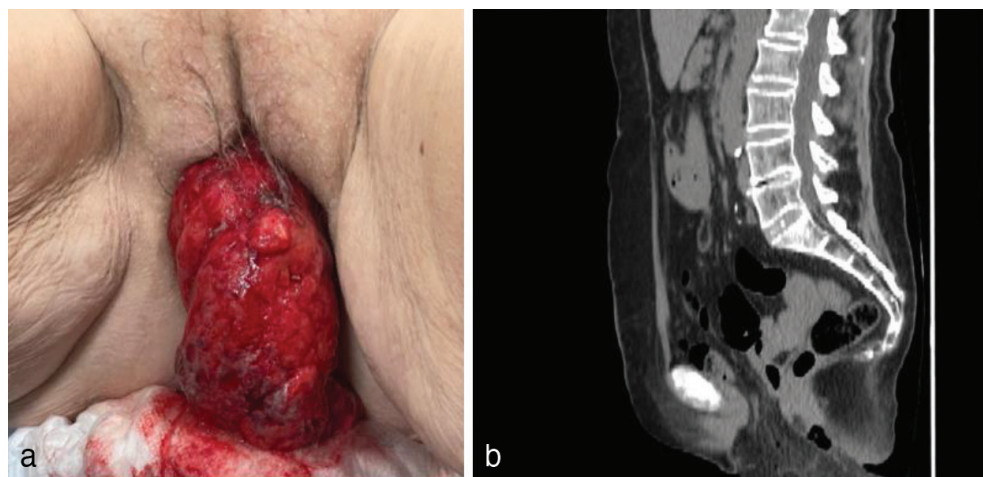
(a) Small bowel protrusion through the vagina on physical examination, (b) computed tomography image showing small bowel herniation through the vagina (sagittal slice)
